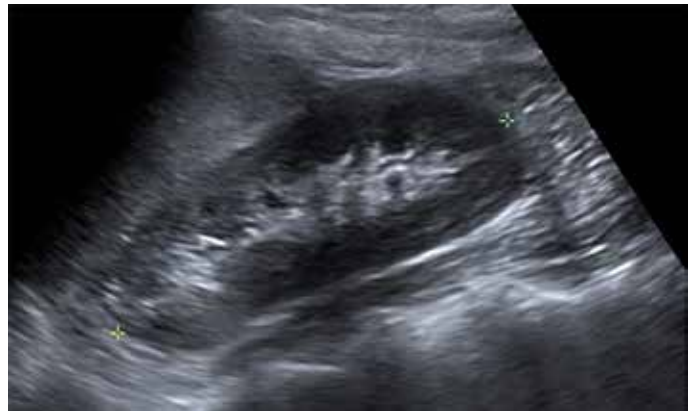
Ultrasound of the patient's left kidney (sagittal view) two years after surgery. The previously noted cystic lesion is no longer seen at the superior pole, and there is no evidence of hydronephrosis.
